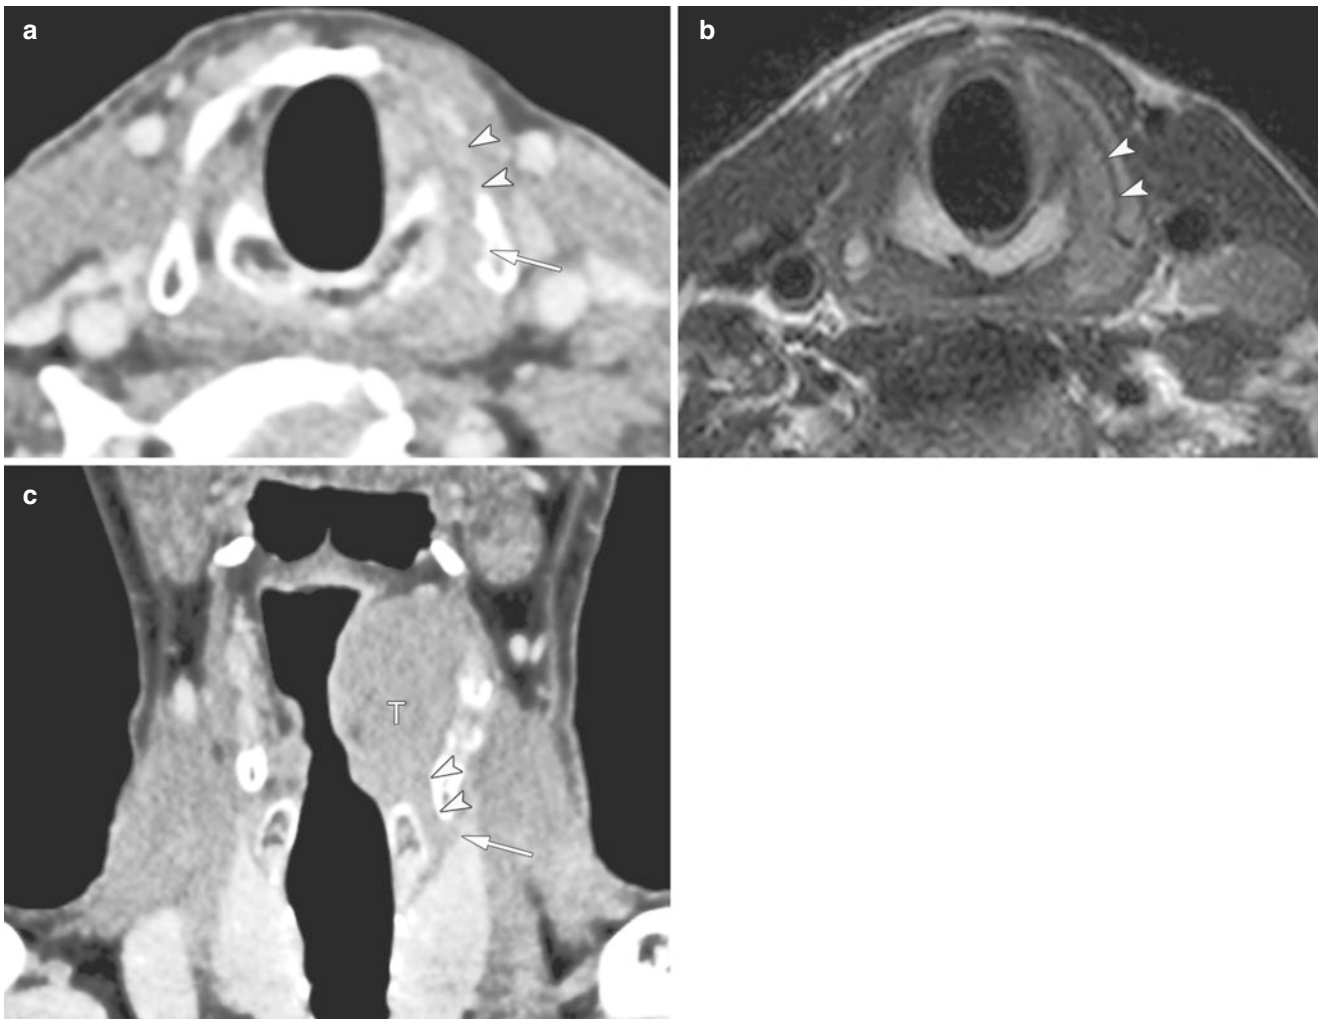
Pyriform sinus carcinoma with extralaryngeal spread through the cricothyroid joint. Axial contrast-enhanced CT (a) and T2-weighted MRI image (b) demonstrate the extralaryngeal spread through the cricothyroid membrane and joint (arrowheads) with thyroid
